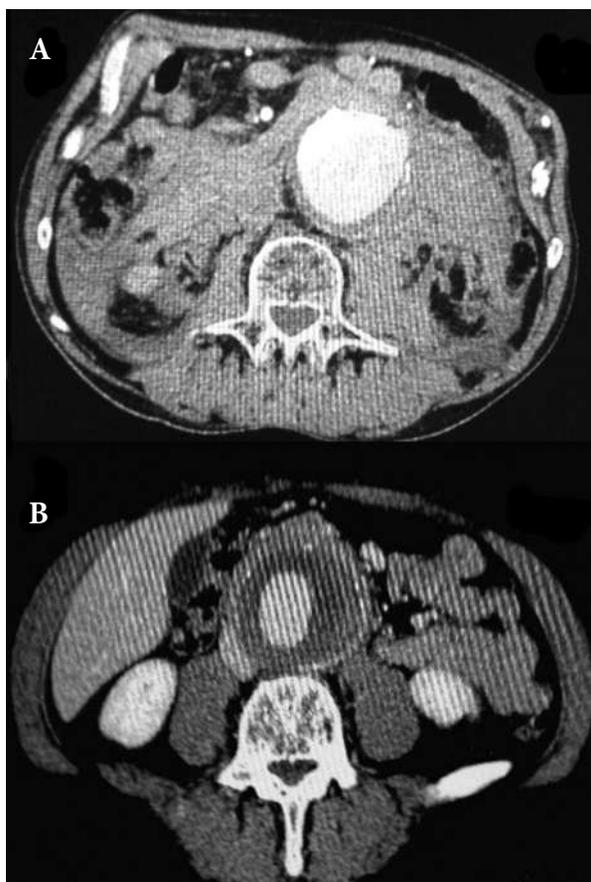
and 2B. A. Ruptured abdominal aortic aneurysm with retroperitoneal hematoma, axial CTA scan; B. Mycotic abdominal aortic aneurysm, axial CTA scan
